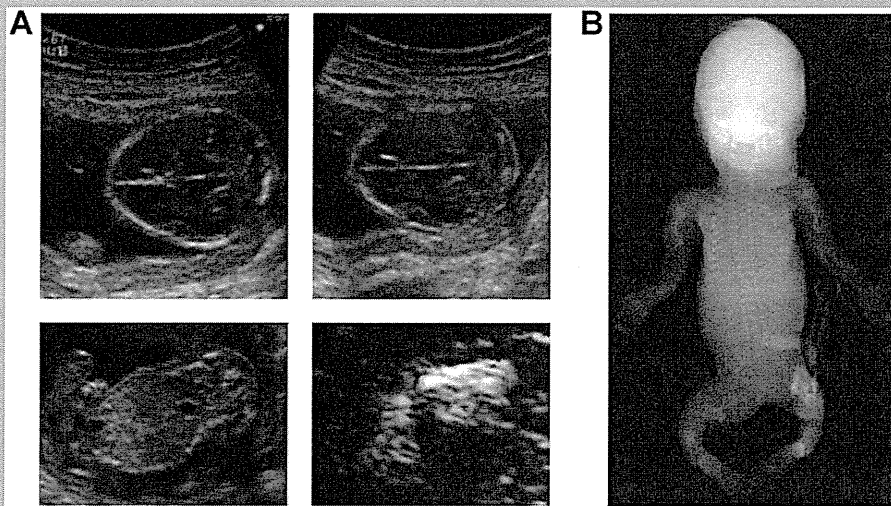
A: Prenatal ultrasonography of the affected second fetus. Upper panels: Easily compressed unossified calvaria. The shape of the calvaria was easily changed before (left image) and after (right image) the compression. Lower left panel: Coronal view of the narrow thorax with short ribs. Lower right panel: Highly curved femur of the affected fetus. B: A postmortem radiograph of the fetus showing beaded ribs, shortened broad and crumpled long bones, and nonossified calvaria.
